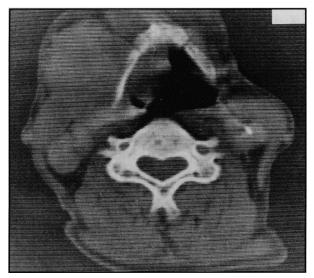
Computed tomography scan of head and neck showing tonsillar mass.
